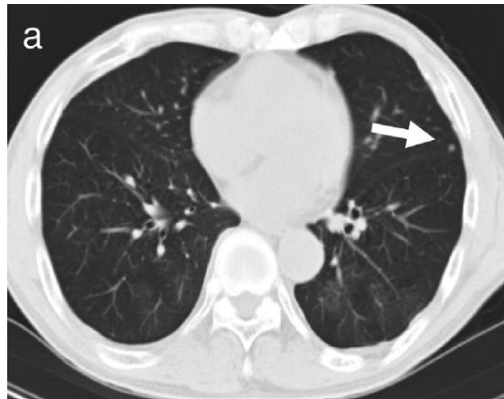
Metastatic lung neoplasm on computed tomography. Temporal progression of pulmonary metastases in individuals diagnosed with osteosarcoma. CT can detect lung metastases above 3 mm in diameter.²³
